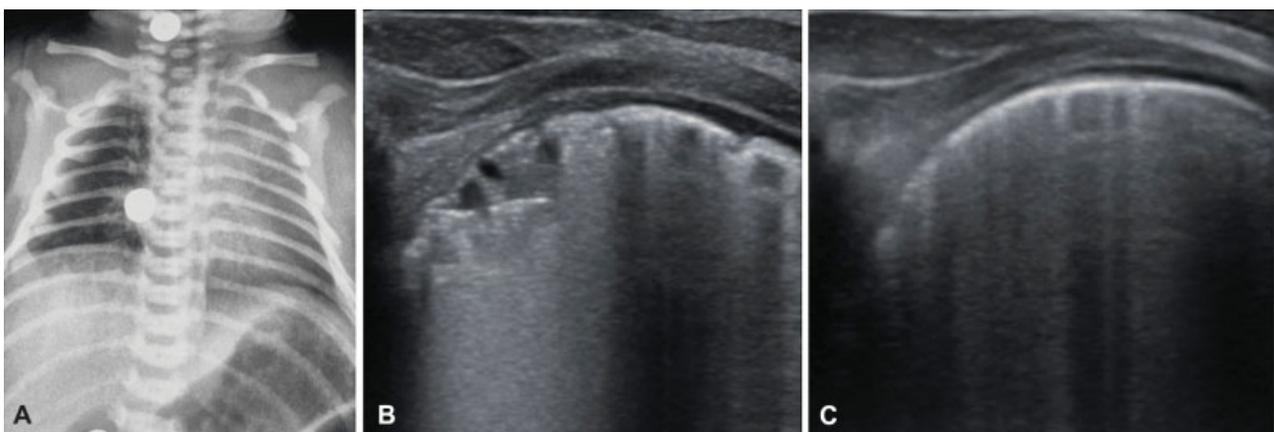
(A) CXR at birth: negative. (B) LUS-DOL 1: right lower lobe multicysts suggesting CPAM type II. (C) LUS-1 month: diffuse B lines but no evidence of cysts. CPAM, congenital pulmonary airway malformation; CXR, chest X-ray; DOL, day of life; LUS, lung ultrasound.
